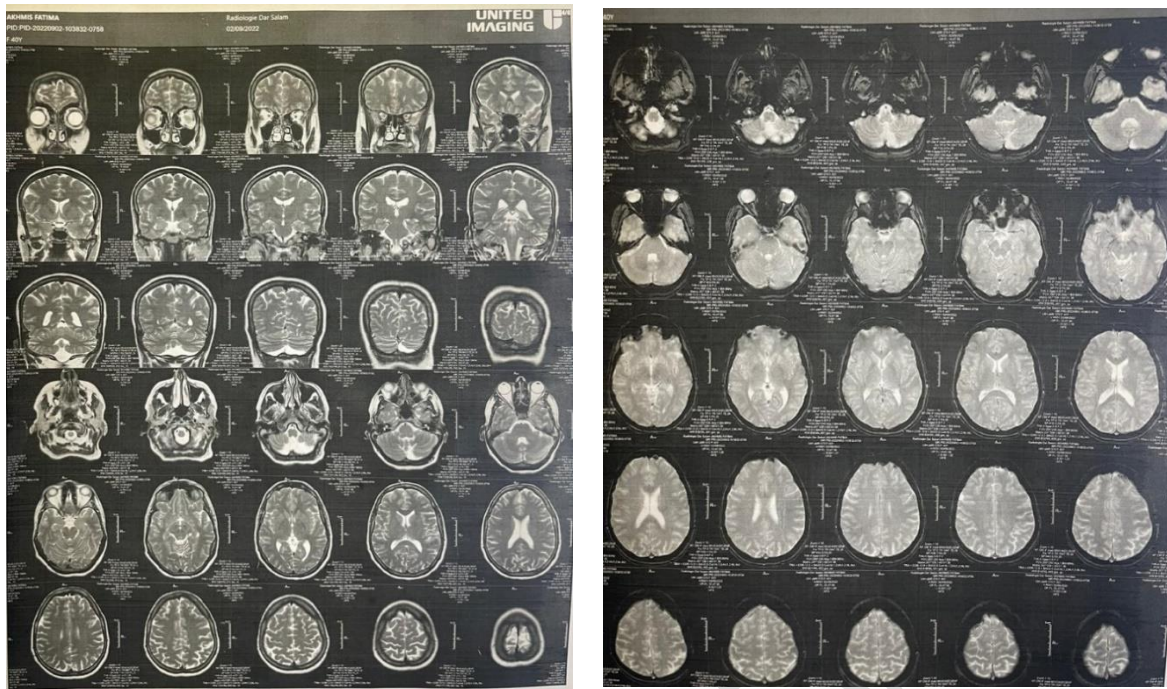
Cerebral MRI of the patient showing no abnormalities
